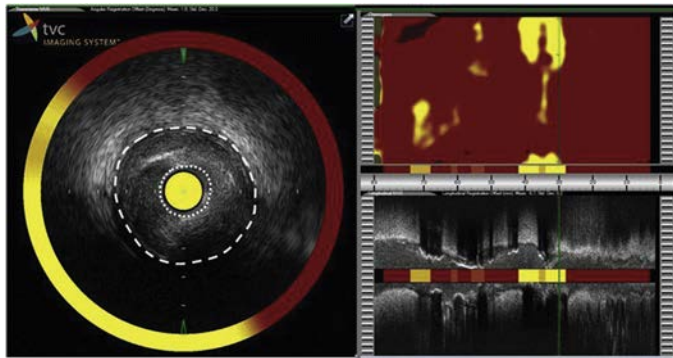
Near-infrared spectroscopy (NIRS) and intravascular ultrasonography (IVUS) images of the culprit lesion in a patient presenting with non-ST-elevation myocardial infarction. The longitudinal NIRS chemogram (top right) displays the lipid signal in yellow and can be superimposed onto the longitudinal IVUS image (bottom right), which provides complementary structural information. The green vertical line designates the lesion location along the artery that is depicted in the cross-sectional image (left panel), which reveals an IVUS-identified attenuated plaque between 3 and 10 o'clock with NIRS-identified lipid core plaque between 5 and 10 o'clock. The dashed circle demarcates the external elastic membrane, and the dotted circle demarcates the lumen-lesion interface. (From Fenning RS, Wilensky RL: *New insights into the vulnerable plaque from imaging studies*. *Curr Atheroscler Rep* 16:397,2014.)
